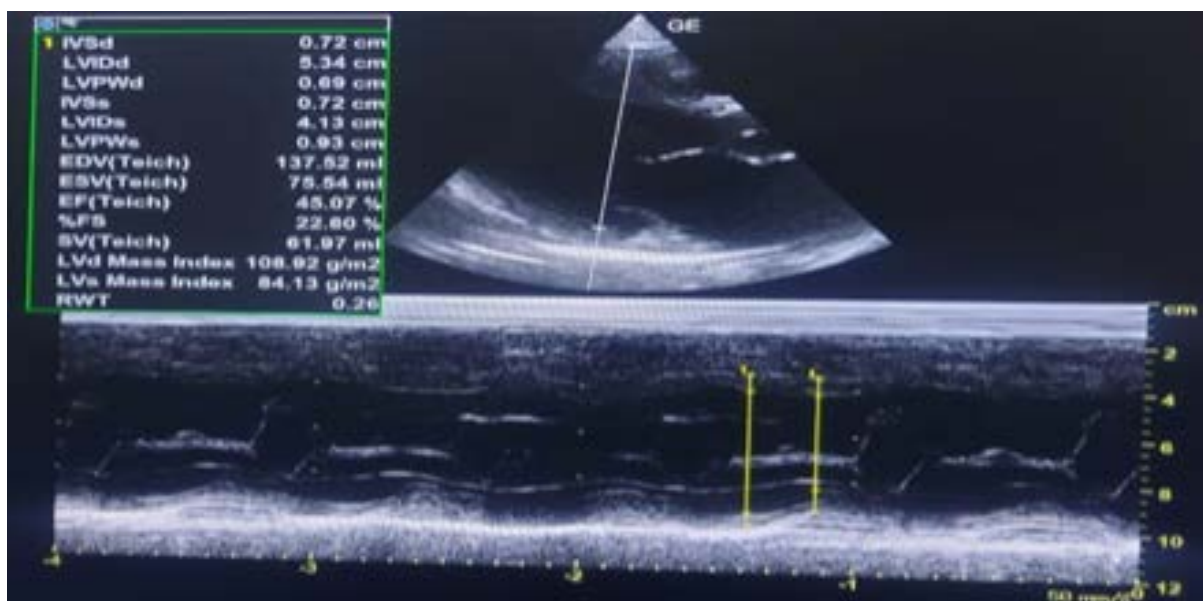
Echocardiography: Dilated LA, RA, LV, Eccentric LVH, Global hypokinetic, Reduce LV systolic LVEF 45 %.
